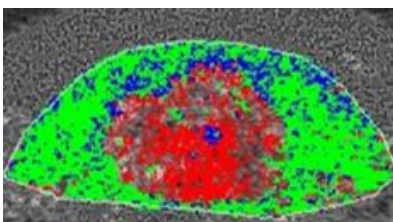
Ultrasound Tissue Characterization images:
